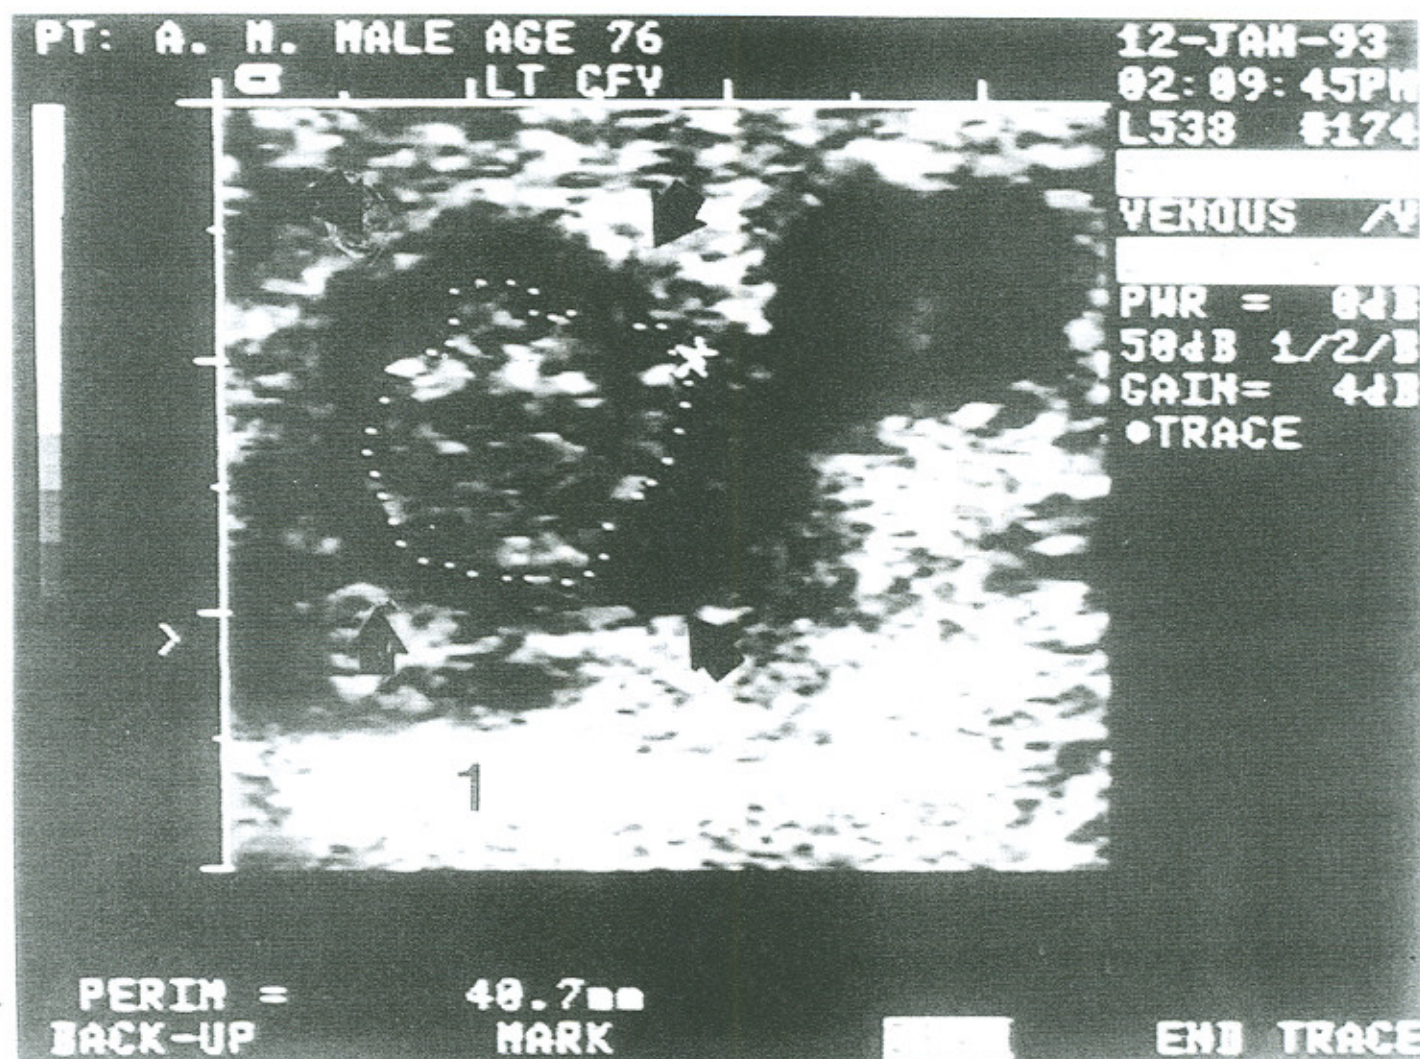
Ultrasound of the left femoral vein (small arrows) demonstrating complete occlusion by a thrombus (dotted margin).
